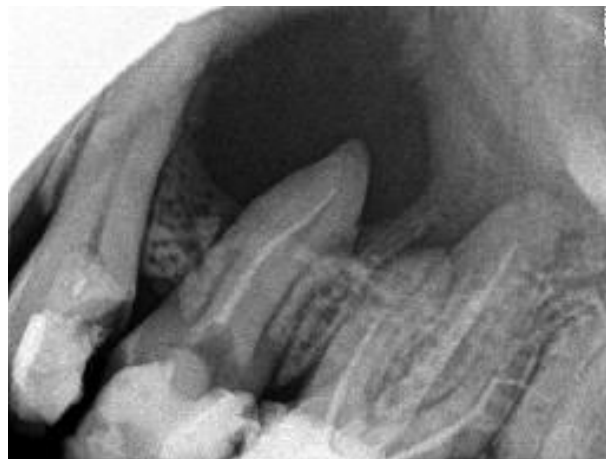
Periapical radiograph showing well-defined radiolucent lesion involving apices of upper left first premolar #24 and upper left second premolar #25. It also revealed inadequate endodontic treatment in the upper left first molar and in the upper left second premolar.
